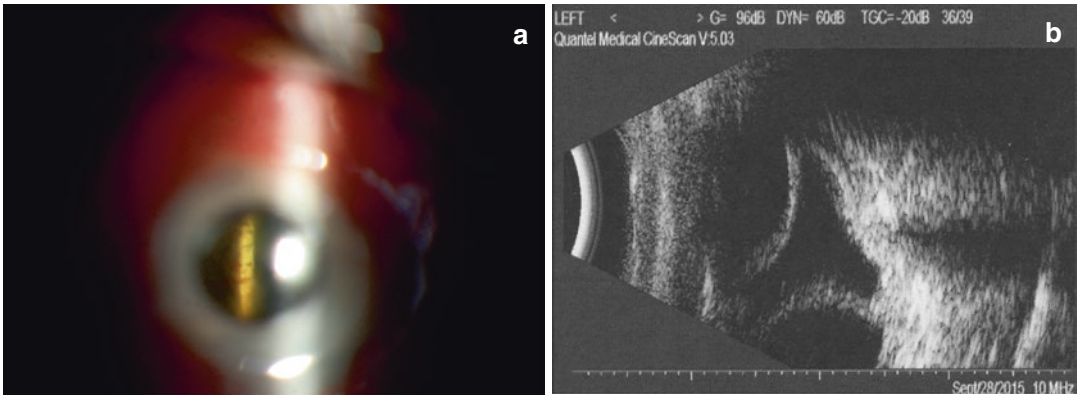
Corneal necrosis around the prosthetic implant resulting in hypotony. (a) Slit lamp of choroidal detachment viewed through KPro I. (b) Ultrasound of choroidal detachment on KPro I
